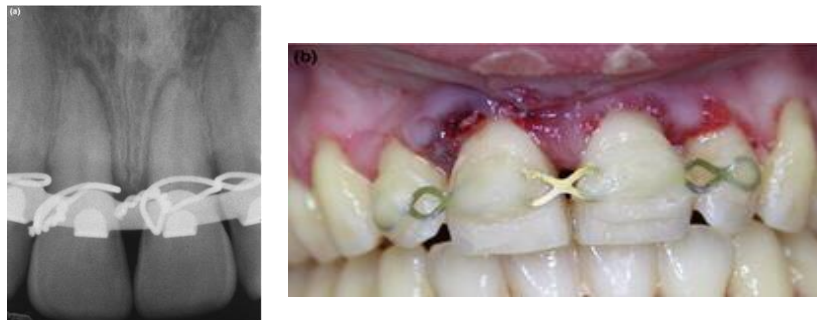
(a) Radiograph of an arch bar secured by wire ligatures. (b) The arch bar and ligature splint has been replaced with a titanium trauma splint. Gross gingival irritation caused by the arch bar splint is evident (B Kahler et al., 2016)
